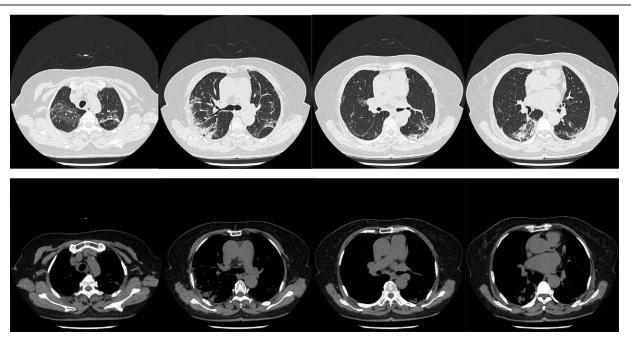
Computed tomography (CT) images after glucocorticoids treatment. We diagnosed the case as IgG4-RLD. The patient was started on oral prednisolone 30 mg/d. After 1 week of treatment, CT showed significant improvement in the areas of consolidations and nodules.
